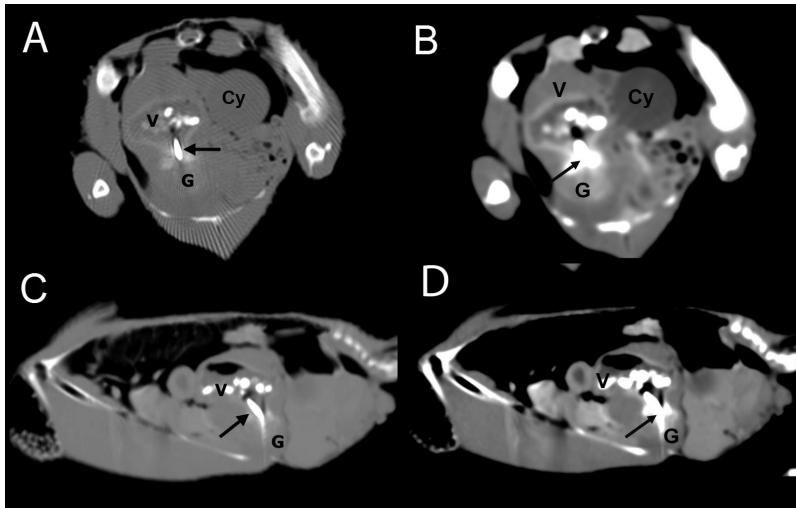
Transverse (A and B) and sagittal (C and D) contrast-enhanced CT images of the pigeon in Figure 1 at the level of the ventriculus (V), obtained with a bone algorithm (A and C) or soft tissue algorithm (B and D). The metallic foreign body (arrows) is visible, extending through the ventral aspect of the ventriculus wall and into the coelomic cavity. Surrounding the ventral aspect of the foreign body is a well-circumscribed mass (G) with a thin contrast-enhanced wall containing a central non-contrast-enhanced region, consistent with a granuloma or abscess. Within the ventriculus, multifocal mineral opacities consistent with grit can be seen. At the right lateral aspect of the ventriculus, 2 round and well-circumscribed nodules were noted that were predominantly of a pure fluid opacity (0 HU) and had a thin wall of soft tissue opacity, compatible with a cystic structure (Cy), such as an ovarian follicle or cyst.
